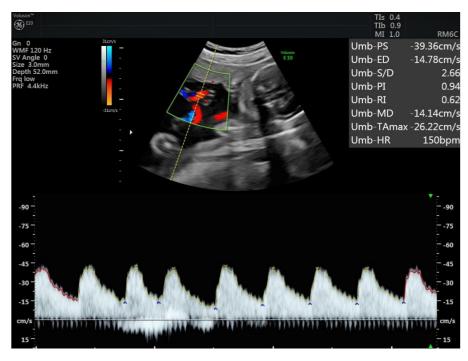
2D Fetal Doppler echocardiography: Doppler measurements.
